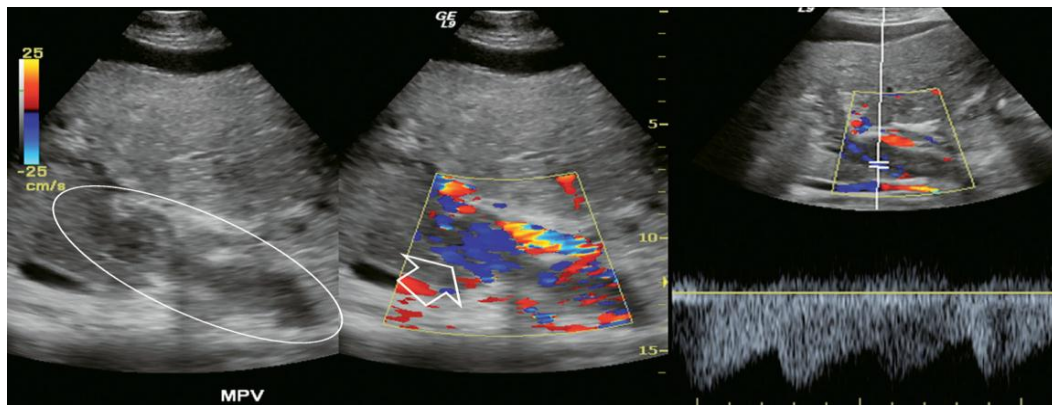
Grayscale imaging, colour Doppler and spectral Doppler tracing over the portal vein in a patient with known advanced hepatocellular carcinoma (HCC). Echogenic material fills the portal vein. Colour Doppler shows numerous small vessels with flow but in a hepatofugal direction. Spectral Doppler tracing over these vessels shows a very low-resistance arterial waveform. This is vascular invasion of the portal vein by hepatocellular
